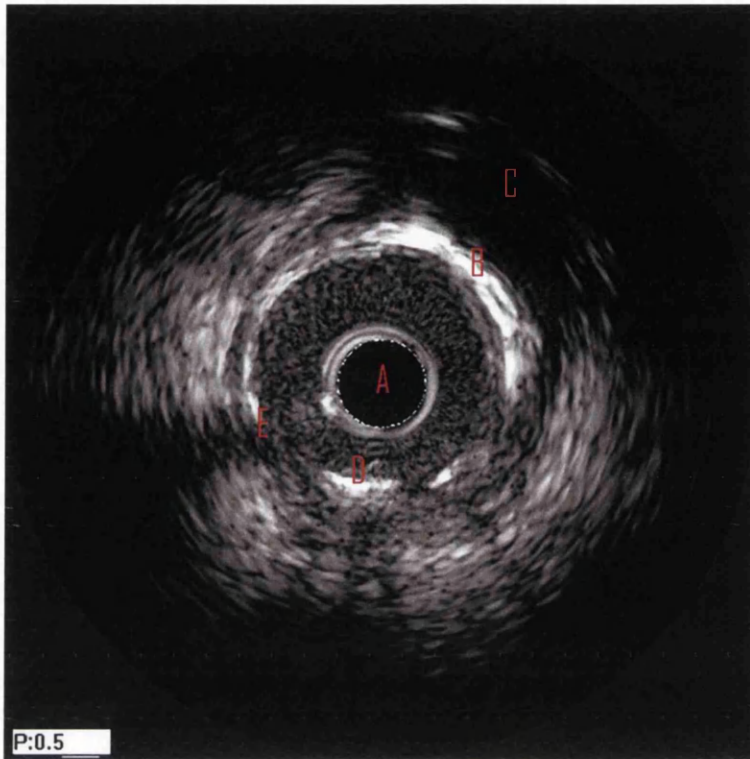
Overview of an IVUS image acquired by 40MHz transducer Boston Scientific ultrasound machine, showing a selection of the artifacts found in the images: A = Catheter Region, B = Calcification (a medium to large bright region), C = Shadow region (as result of calcification), D = Stent (a single small, bright region with underlying shadow), E = Guidewire shadow (a long regularly shaped shadow region, often extending into lumen with bright regions along it).
